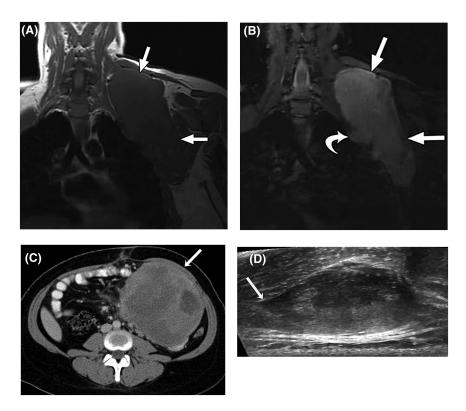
(A) T1-weighted and (B) T2-weighted, fat-suppressed magnetic resonance images in the coronal plain of a 28-year-old woman with a large desmoid tumor (DT) in the shoulder region (straight arrows). The curved arrow indicates a nodular protrusion that raises concern for pleural invasion. (C) Axial, contrast-enhanced computed tomography image from a 27-year-old woman with a nonresectable, solitary intra-abdominal DT not associated with familial adenomatous polyposis. An arrow indicates a large, well defined mass adherent to the small bowel and mesenteric vessels. (D) Transverse ultrasound of a sporadic right paraspinal musculature extra-abdominal DT in a 26-year-old woman. Linear fascial extension (tail sign) is indicated by the arrow. A and B reprinted from: Shinagare AB, Ramaiya NH, Jagannathan JP, et al. A to Z of desmoid tumors. *AJR Am J Roentgenol.* 2011;197(6):W1008-W1014,⁴ with permission from the American Roentgen Ray Society. Copyright©2011, American Roentgen Ray Society. C and D reprinted from: Braschi-Amirfarzan M, Keraliya AR, Krajewski KM, et al. Role of imaging in management of desmoid-type fibromatosis: a primer for radiologists. *Radiographics.* 2016;36(3):767-782,³⁷ with permission from The Radiological Society of North America. Copyright©2016, The Radiological Society of North America.
